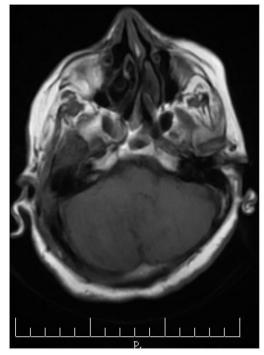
T1-weighted image. the mass was predominantly hypointense and had typical prominent hypo- and isointense striations.
